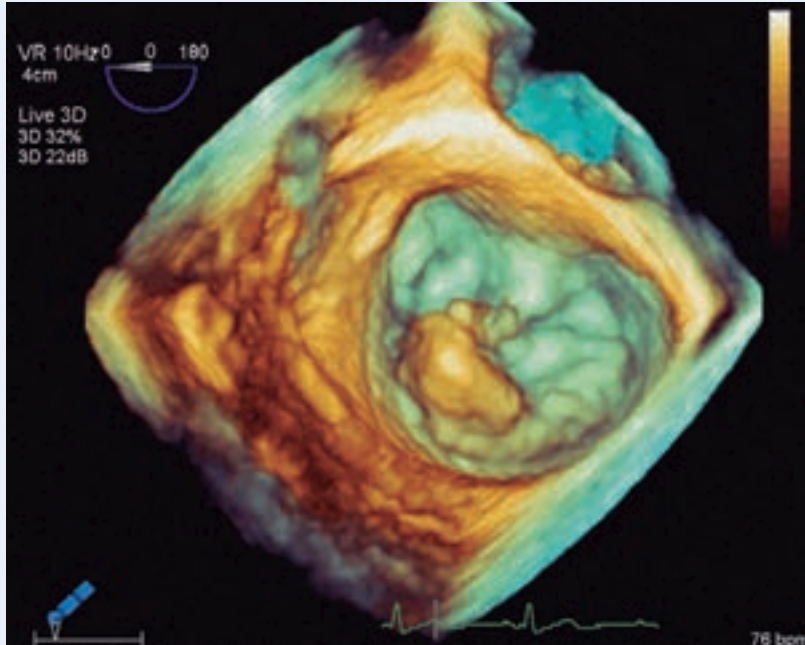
Three-dimensional echocardiogram demonstrating mitral valve prolapse
